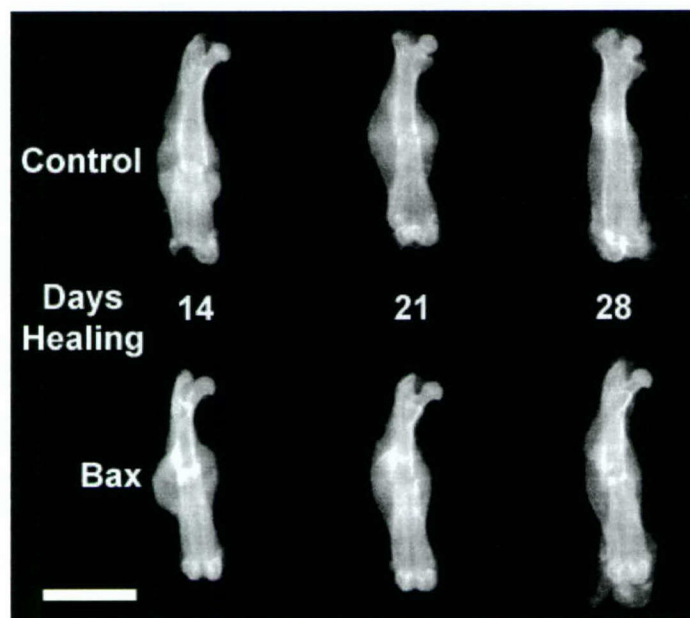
X-ray photograph comparing healing in the Bax knockout with C57BL/6 control at 14, 21 and 28 days post-fracture. The slightly more mineralized callus at 28 days healing supports pQCT data and suggests that a lack of Bax expression delays remodeling of the callus to cortical bone in the later stages of fracture healing. Scale bar = 5 mm.
